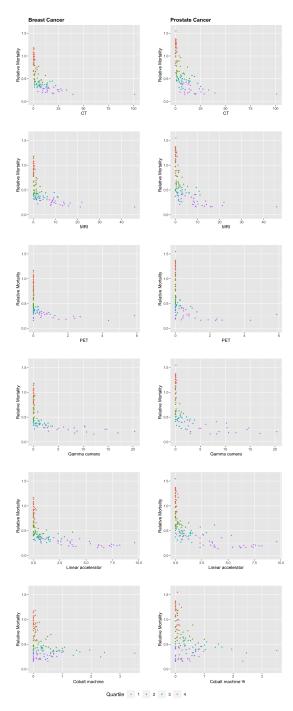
Relative mortality of breast and prostate cancer plotted against number of diagnostic devices (CT, MRI, PET, Gamma camera) and treatment technologies (linear accelerator and cobalt machine) per million population. Each point represents a country, colour-coded by the corresponding development quartile
